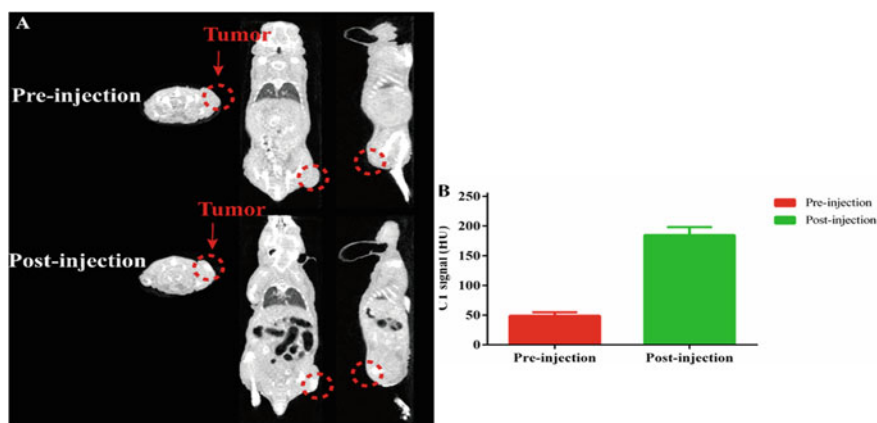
In vivo CT imaging of BiF₃Ln@PVP NPs, a CT images before and after the injection of BiF₃Ln@PVP NPs (tumor site is shown in red circle), b Corresponding CT values (HU). Reproduced from Ref. [61] with the permission of the Creative Commons Attribution 4.0 International License (<http://creativecommons.org/licenses/by/4.0/>). Copyright 2021, Springer
